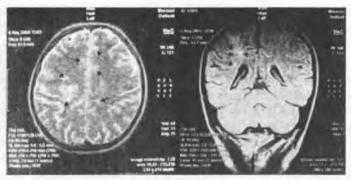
Head MRI showed T2 and FLAIR hiperintensive lesions, with no contrast enhancement. localized in periventricular white matter of both parietal and frontal lobes
